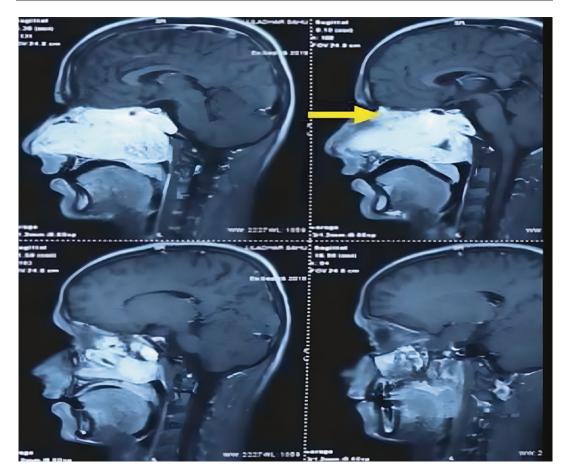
Para-sagittal view in MRI showing the lesion reaching up to the cribriform plate
